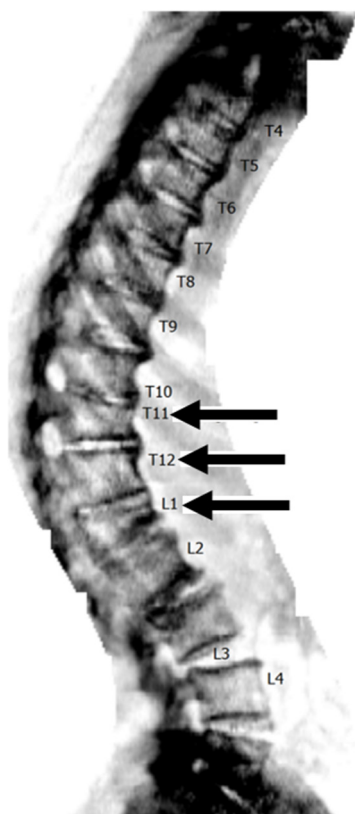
Vertebral fracture assessment (VFA) on lateral DXA demonstrates multiple wedge-shaped vertebral fractures in a patient with osteoporosis. DXA, dual-energy X-ray absorptiometry.
